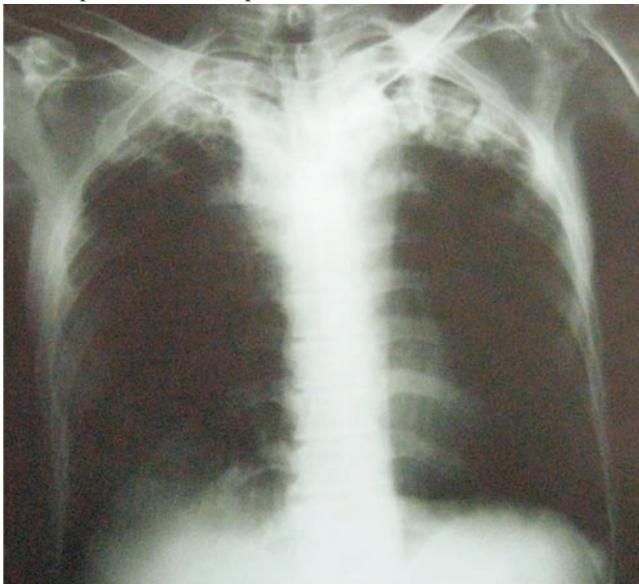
Chest radiograph showing bilateral upper zone fibrosis suggestive of old Koch's.
